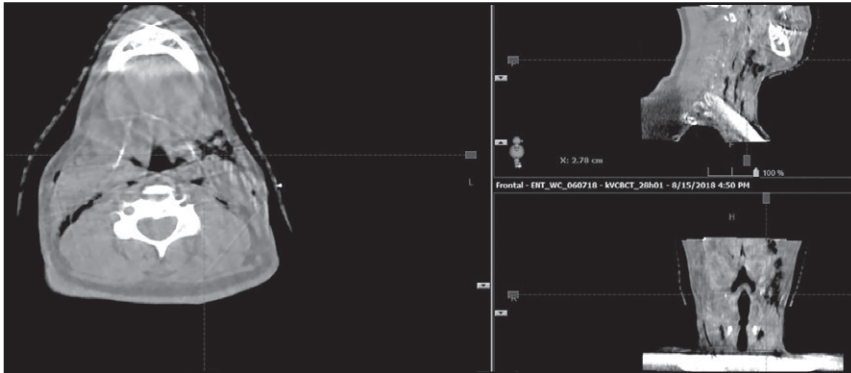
Subcutaneous emphysema in the neck incidentally detected on daily cone-beam computed tomography (CBCT).
